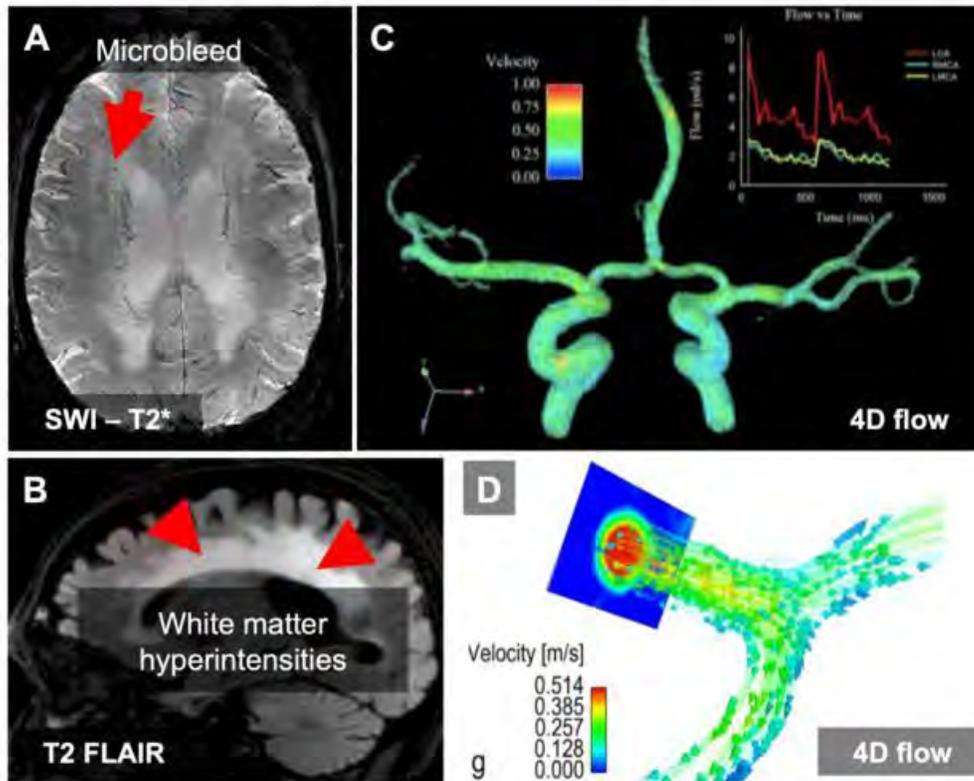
Imaging features of Alzheimer's Disease (AD). Multiple imaging signs are typically described in AD, including microbleed (A) and white matter hyperintensities (B). 4D-flow MRI is an advanced and innovative MRI technique used to study the cerebral blood flow parameters in AD (C, D).
